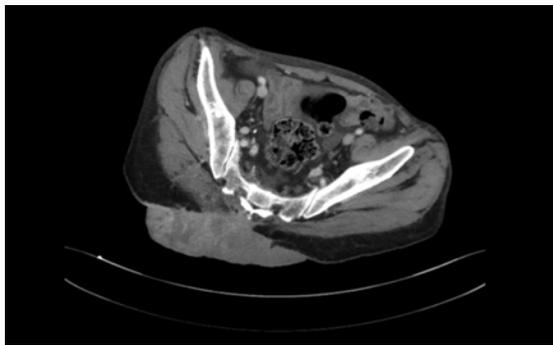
CT scan showing absence of inguinal or presacral lymph node enlargement.
